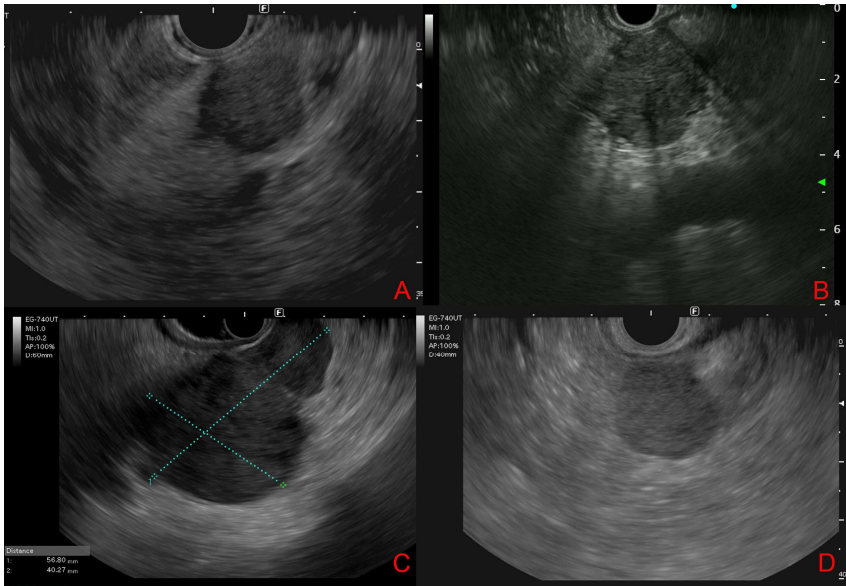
Endoscopic ultrasound features of pancreatic metastases. A-B: From renal cell carcinoma (solid, round, well-defined hypoechoic lesions). C: From hepatocellular carcinoma (bilocular hypoechoic lesion). D: From Lymphoma (nodular, hypo-isoechoic lesion with a relatively well-defined boundary).
